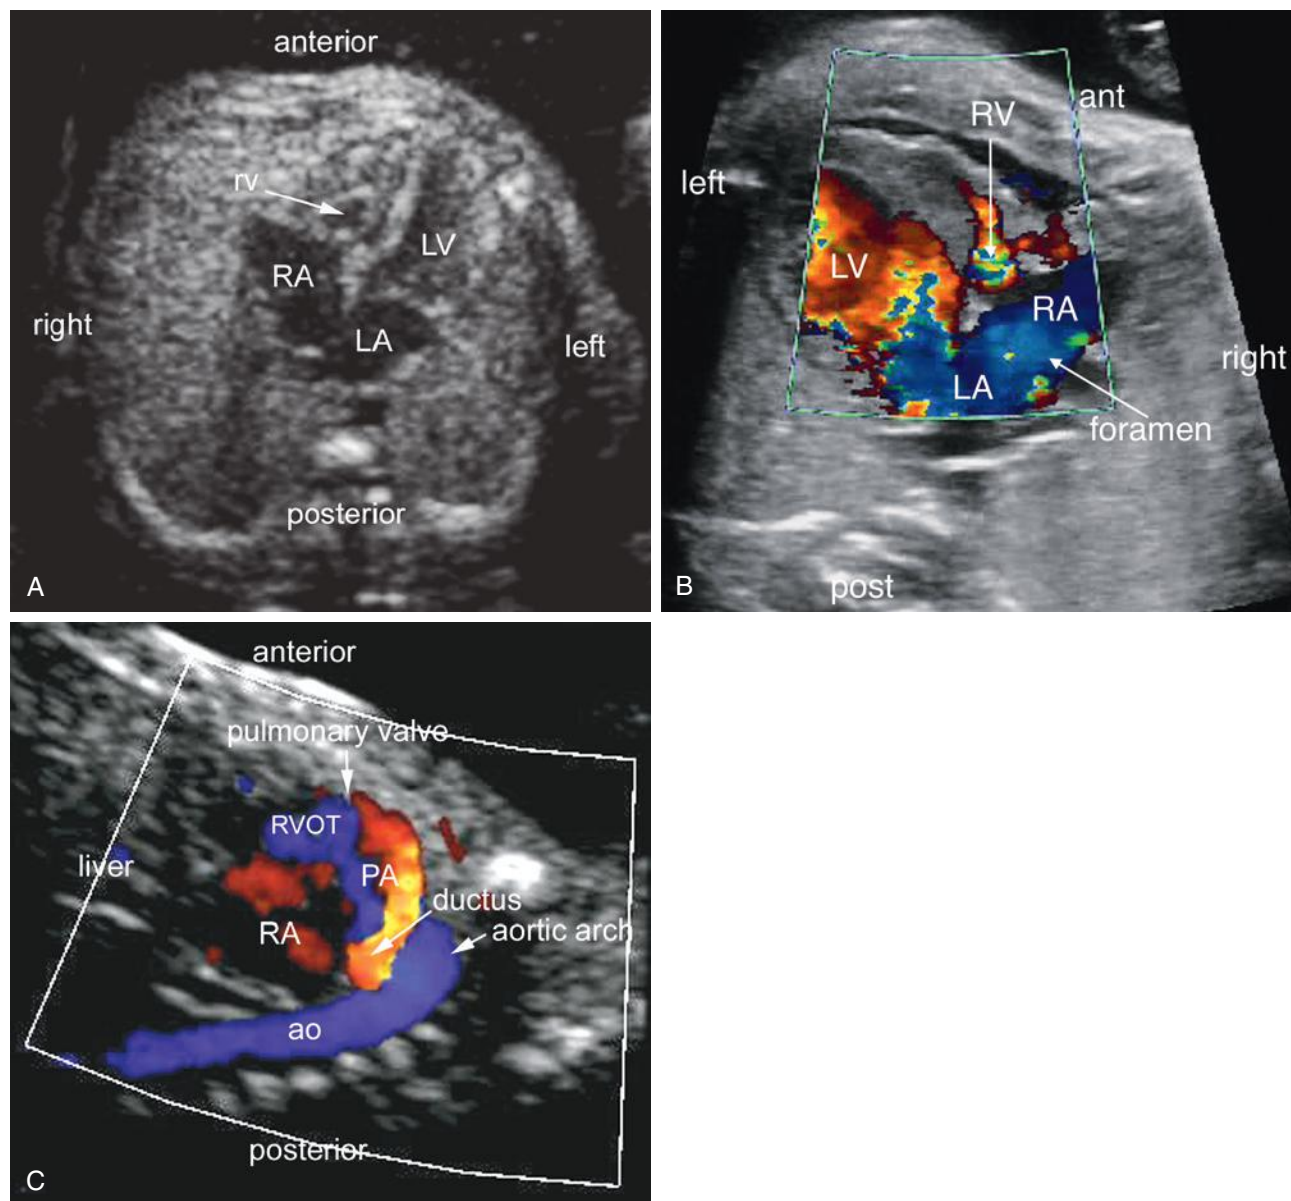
Pulmonary atresia with intact ventricular septum. A, Four-chamber view shows severe hypoplasia of the right ventricular cavity (rv) and markedly thickened right ventricular free wall. B, A four-chamber view using color Doppler shows minimal inflow into the right ventricle (RV). C, Ductal arch view with color Doppler shows left-to-right shunt across the ductus. The blood flow from the right ventricle (blue signal in right ventricular outflow tract [RVOT]) and the retrograde flow in the main pulmonary artery (red signal) collide at the atretic pulmonary valve. ant, anterior; ao, aorta; LA, left atrium; LV, left ventricle; PA, main pulmonary artery; post, posterior; RA, right atrium.
